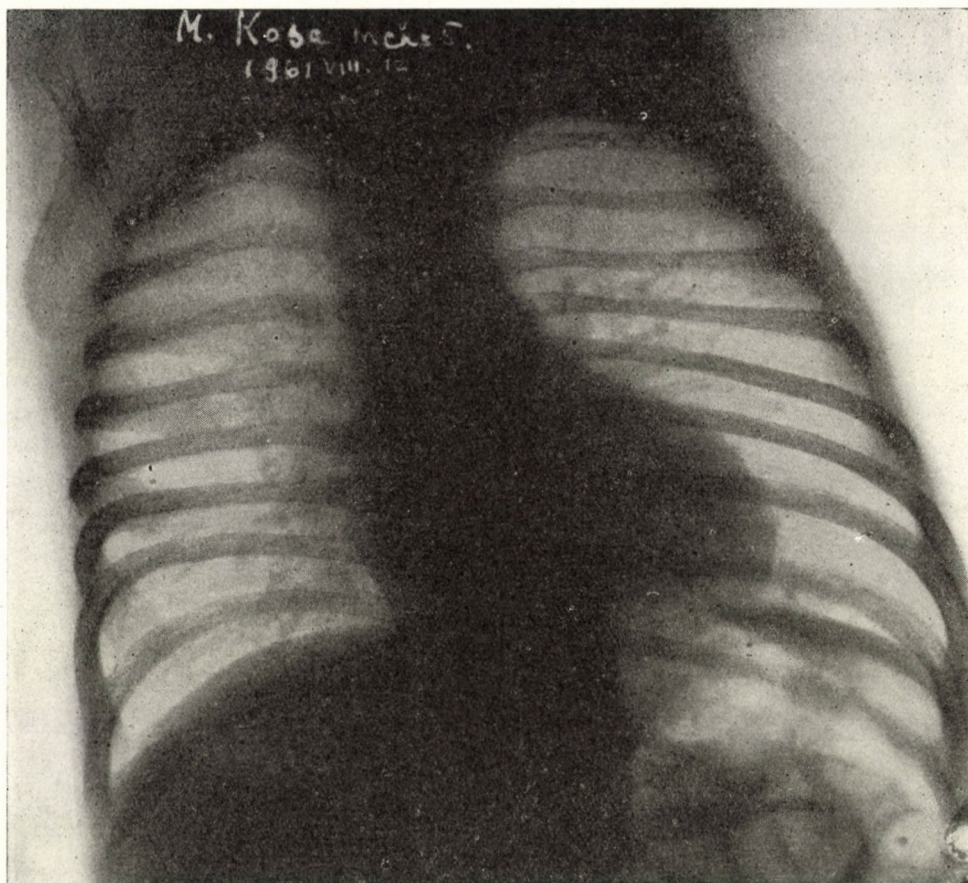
Case 2 (K. M.) Chest radiograph at 5 months of age. Increased pulmonary pattern, emphysema, deep-positioned diaphragm
